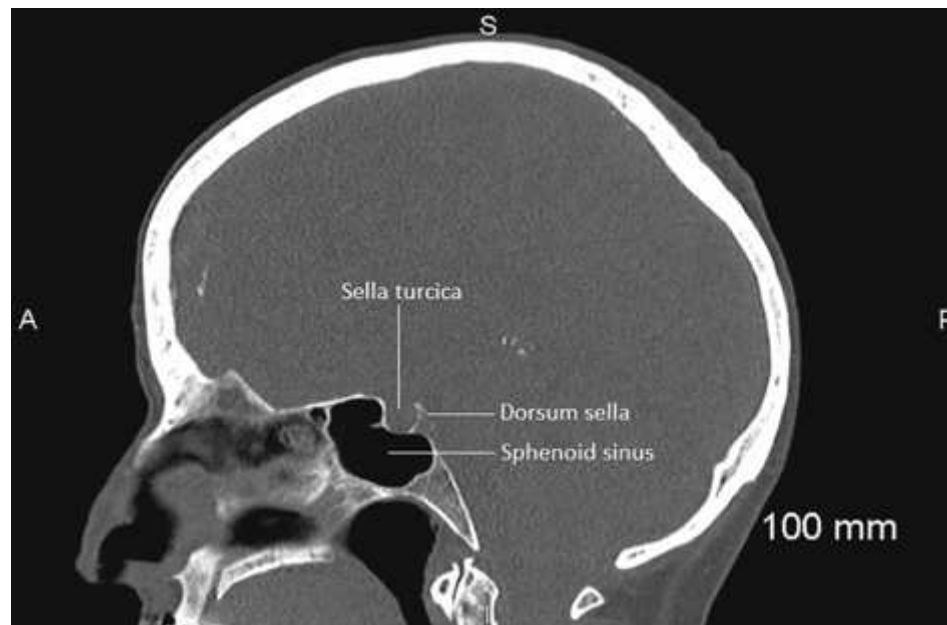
Sagittal CT scan of sella turcica and sphenoid sinus. Courtesy Natalie Reece, RT(R) (CT)(MR), NEA Baptist Memorial Hospital, Jonesboro, AR.
